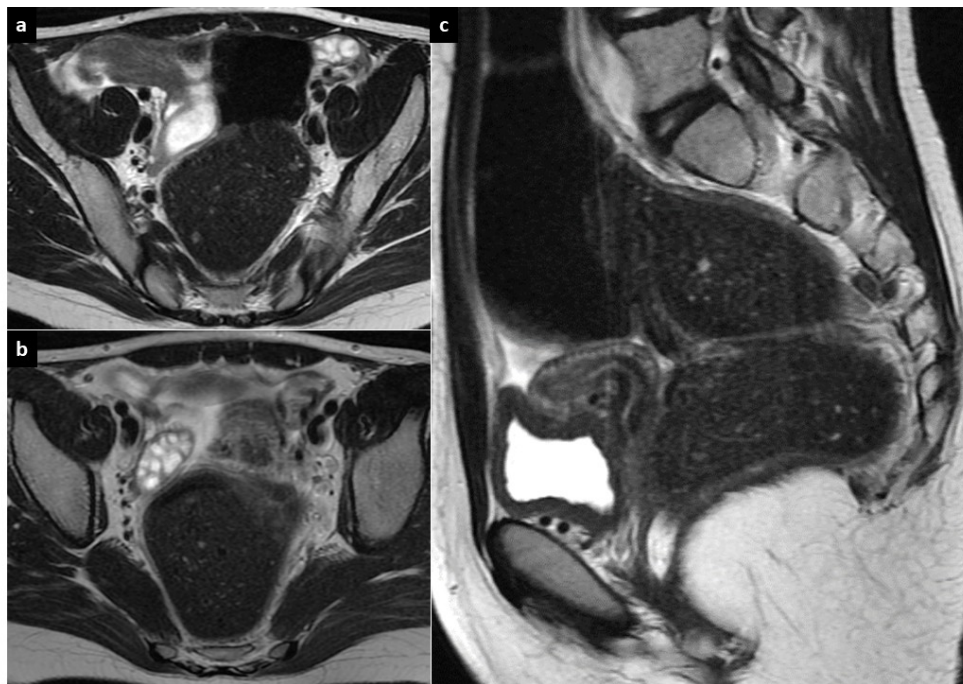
Magnetic resonance imaging (MRI) in T2-weighted images; A. Axial plane, sigmoid colon distended by feces and gas, normal left ovary; B. Axial plane, sigmoid colon distended by feces, normal right ovary; C. Sagittal plane, giant sigmoid colon distended by feces and gas, normal uterus
